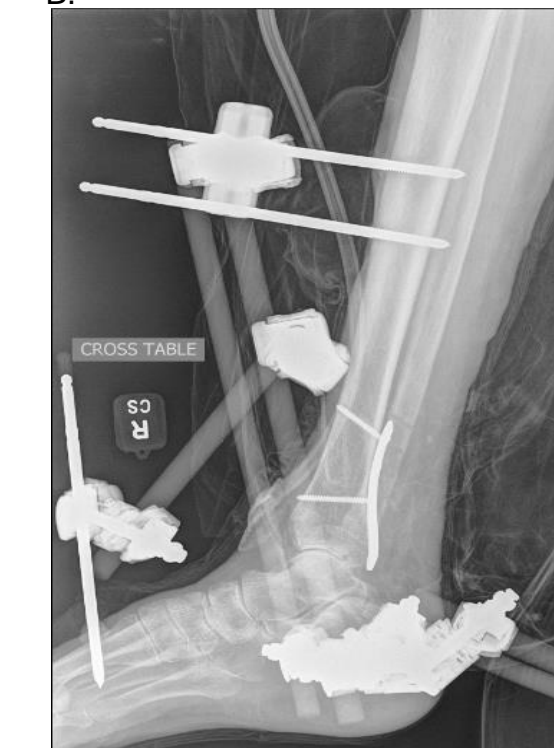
AP(A) and lateral(B) radiographic views post application external fixator
